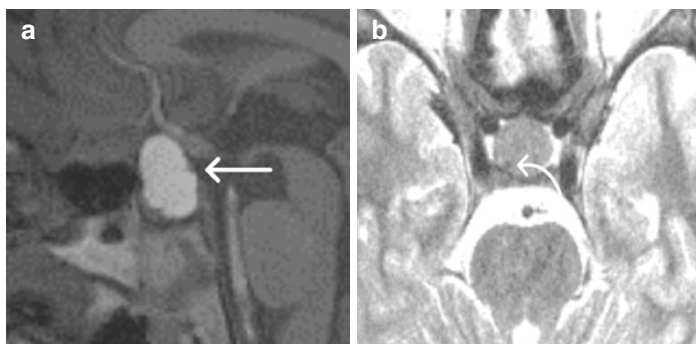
Rathke cleft cyst (RCC) MRI images of a 10-year-old boy with RCC presenting with new onset diabetes insipidus. (a) Unenhanced T1 sagittal image showing hyperintense cyst in the sella and suprasellar region (straight white arrow). (b) Axial T2-weighted imaging showing hypointense / dark content within the cyst with a peripheral hypointense/dark nodule (curved arrow)
